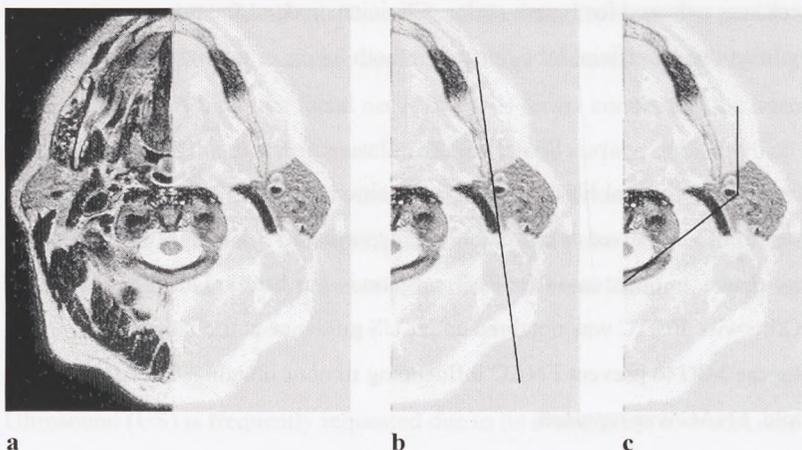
(a) MR image of the neck at the level of the parotid gland. Ariyoshi's facial nerve (FN) line (b) connecting the lateral surface of the posterior belly of the digastric muscle to the lateral surface of the cortical bone of the ascending ramus of the mandible, and the Utrecht (U) line (c) connecting the most dorsal point visible of C1 or C2 vertebra to the retromandibular vein, are used to indicate the presumed course of the facial nerve.
